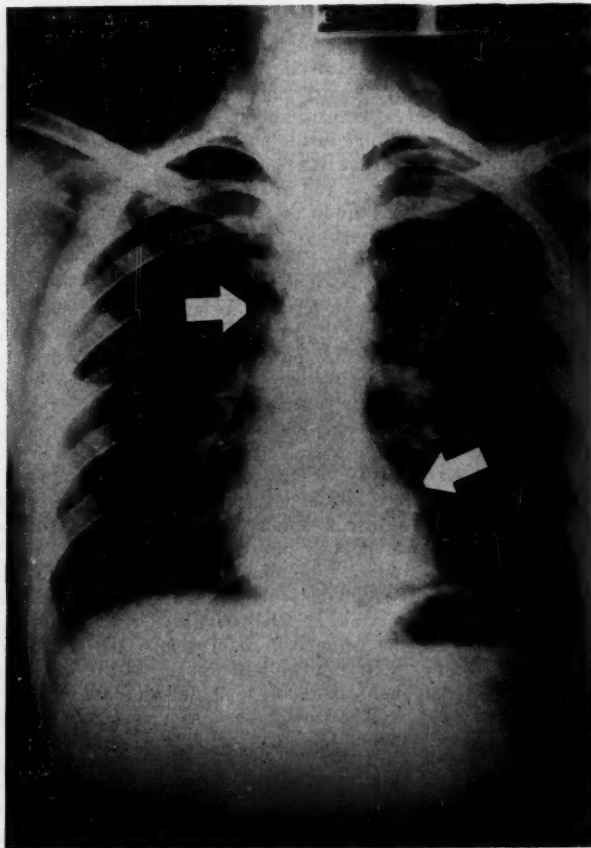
Case 15.* Chest x-ray taken on day of admission, showing mediastinal and subcutaneous emphysema. Arrows point to the pleural lining bordering the mediastinum. There is a small pneumothorax in the right apex.
